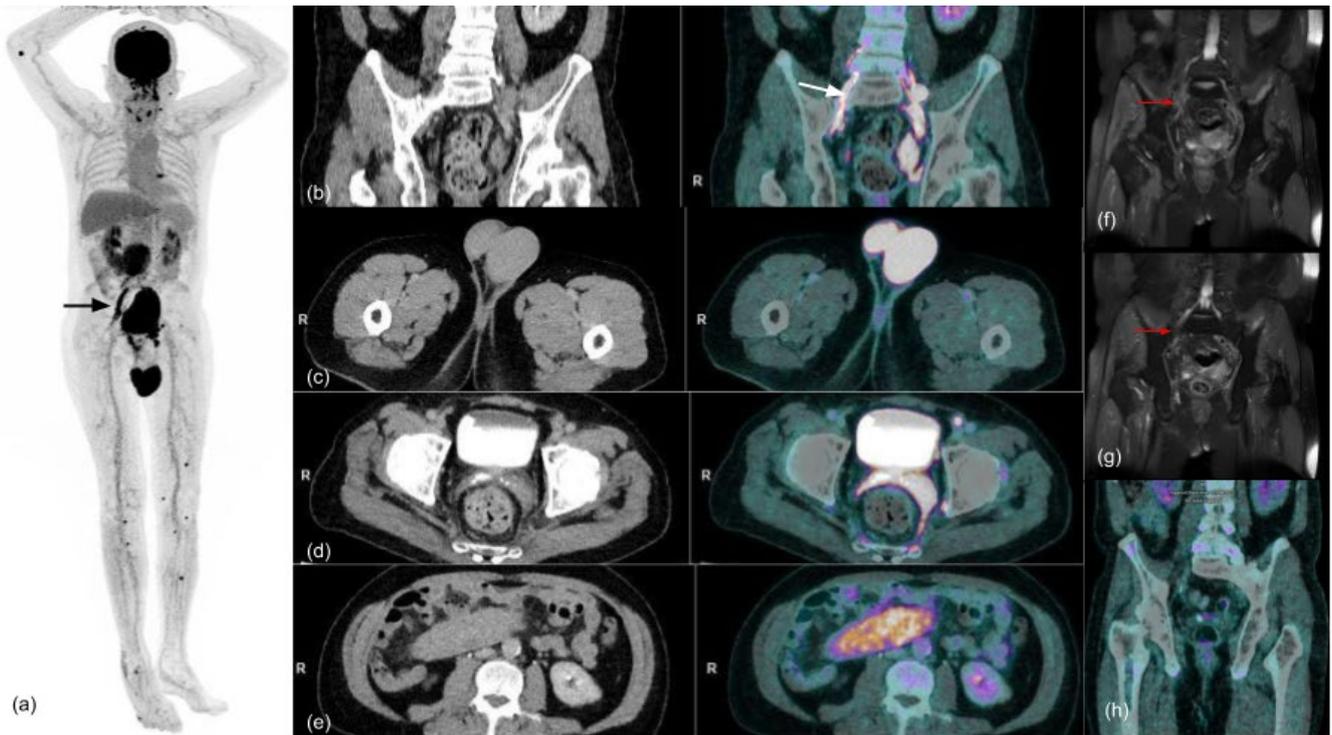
(a) Initial ^{18}F -FDG PET MIP and (b) coronal fused PET/CT show increased FDG activity along the course of L4-L5 and L5-S1 nerve roots. (c) (d) (e) Axial fused PET/CT shows increased FDG activity in the bilateral testes, seminal vesicle, spermatic cord, and intraabdominal mass. (f) and (g) Representative coronal T2FS images show thickening and T2 heterogeneous signals of the bilateral L4-L5 and L5-S1 exiting nerve roots most evident on the right (red arrow). (h) Post-treatment coronal fused PET/CT shows metabolic resolution in the regions of L4-L5 and L5-S1 nerve roots.
